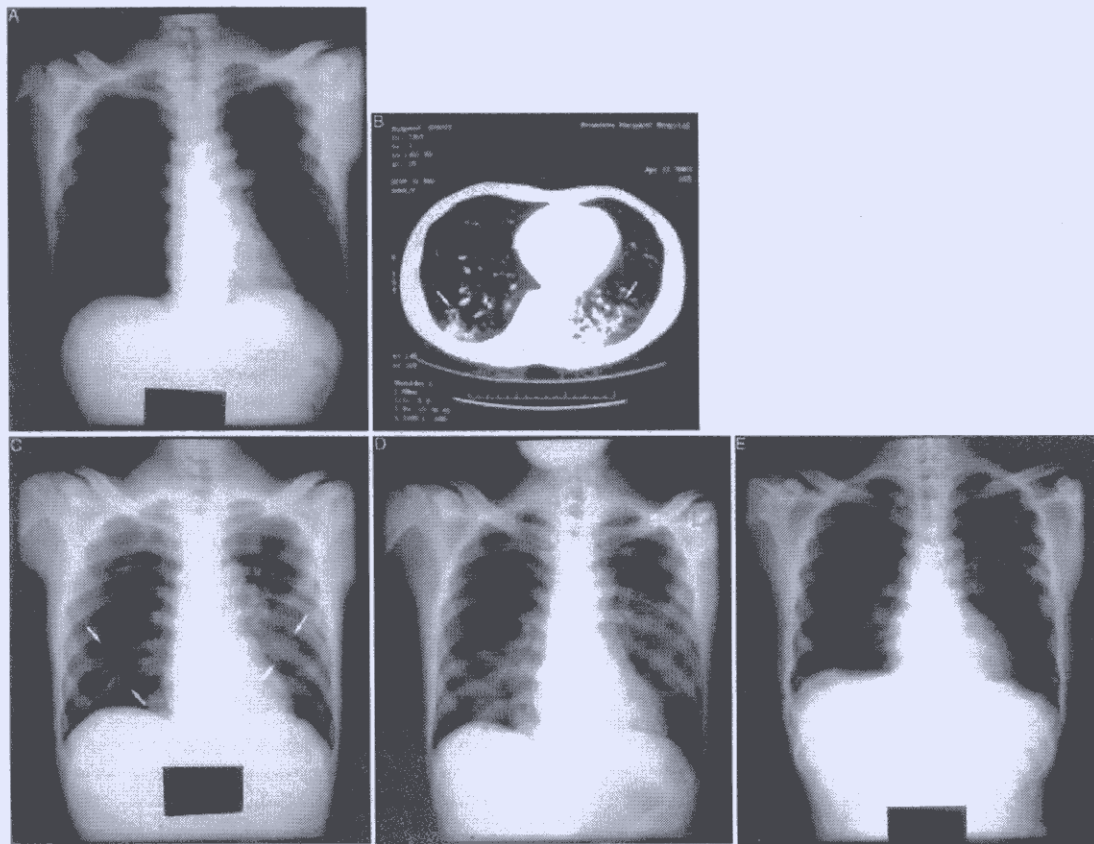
Radiographic images of patient 1. (A) Chest radiograph on day 6 after onset of symptoms showed no consolidation. (B) High-resolution CT scan of the thorax on day 7 showing patchy consolidation and ground-glass shadowing in both the left and right lower lobes. (C) Chest radiograph on day 9 began to reveal air-space shadowing over the left middle zone and right lower zone. (D) Chest radiograph during maximum deterioration (day 11) showing extensive pulmonary infiltrates over bilateral lung fields. (E) Chest radiograph on day 20 showing improvement of lung shadows after therapy.
